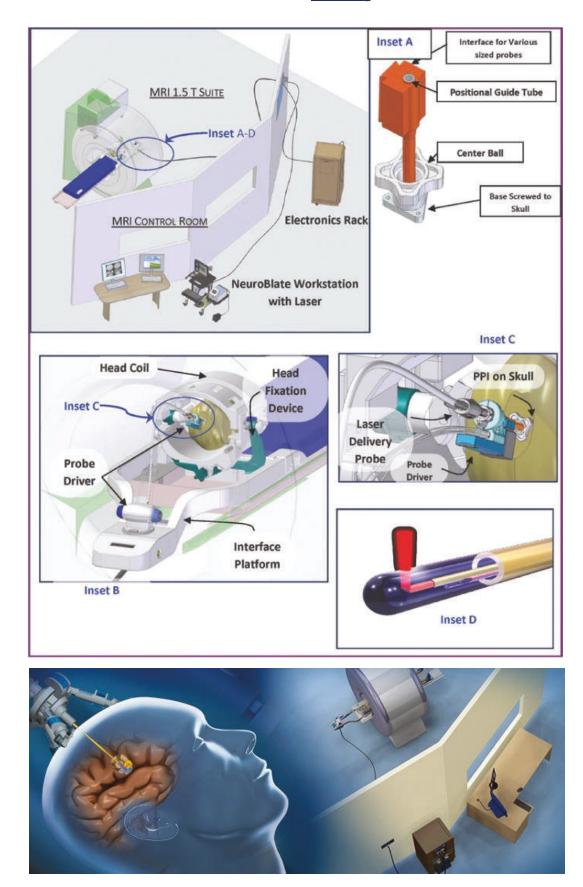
Layout for the MRI suite, laser, and fiber delivery system.
